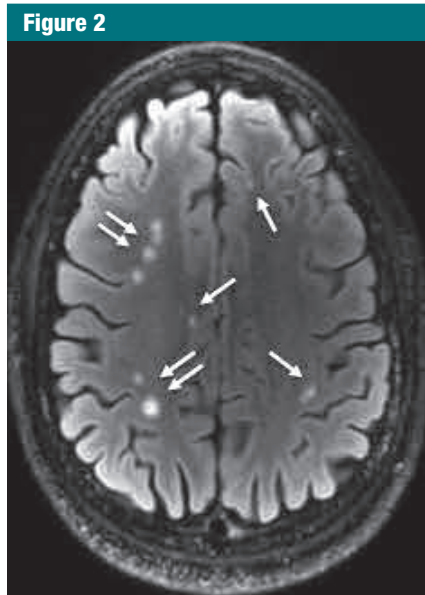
Axial T2 FLAIR image shows multiple white matter T2-weighted hyperintense areas (arrows) in a 28-year-old man with blast-related mild TBI. This patient had a total of 76 lesions on all sections.
